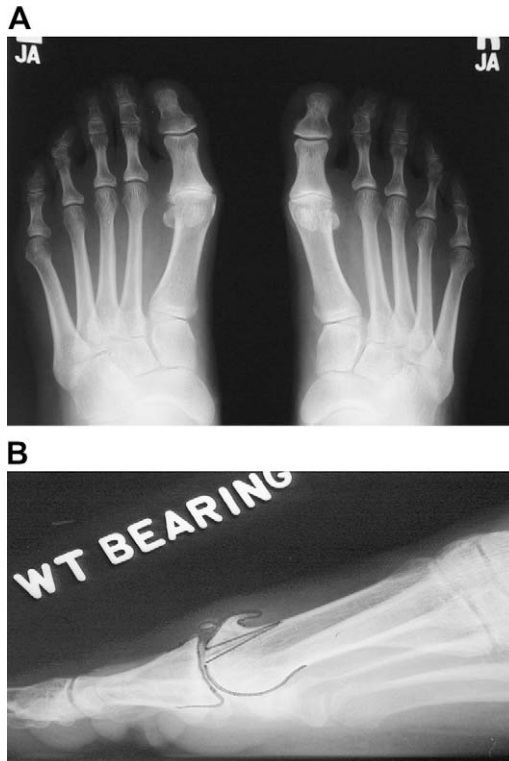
Grade 3 hallux rigidus. (A) The first MTP joint has a definite flat appearance with proliferating marginal osteophytes, loss of cartilage space, and loose body formation. Clinically, patients have a stiff toe (10° of dorsiflexion typically) but no pain at the mid-range of the joint. Primarily they have pain at the extremes of motion caused by impingement of the dorsal osteophyte. The elevatus is markedly increased and the radiodensity around the joint is increased compared with grade 2. Elevatus is associated with worsening MTP joint function. Hallux interphalangeus (angular deformity of the proximal phalanx) is clearly notable and is associated with advanced hallux rigidus—often grades 2, 3, and 4. (B) The lateral radiograph demonstrates some plantar cartilage space remaining.
